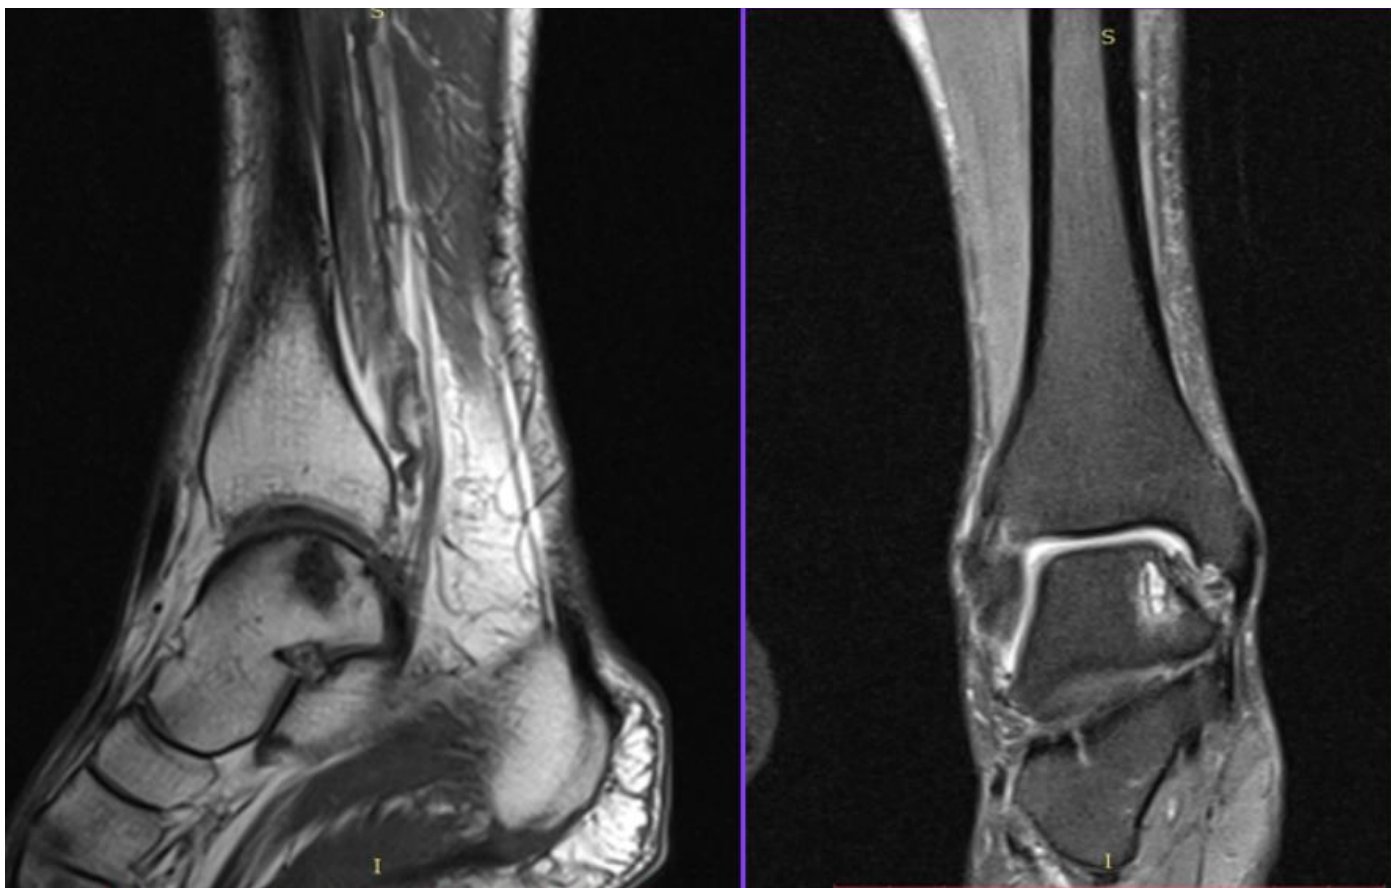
Preoperative MRI T1/PD TSE FS scans of the right talus bone in November 2018. revealing subchondral cyst
